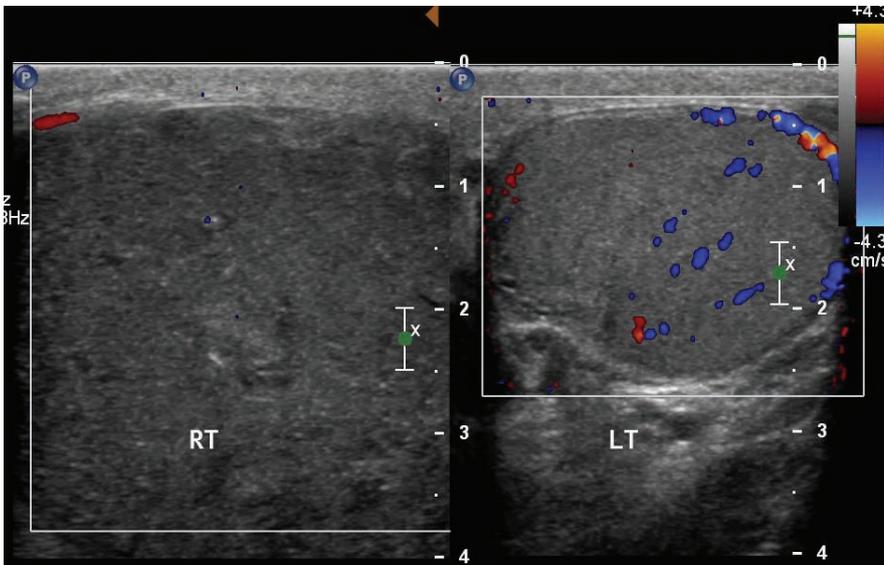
Doppler ultrasound revealed an enlarged right testicle devoid of blood flow. The left testicle appeared normal.
